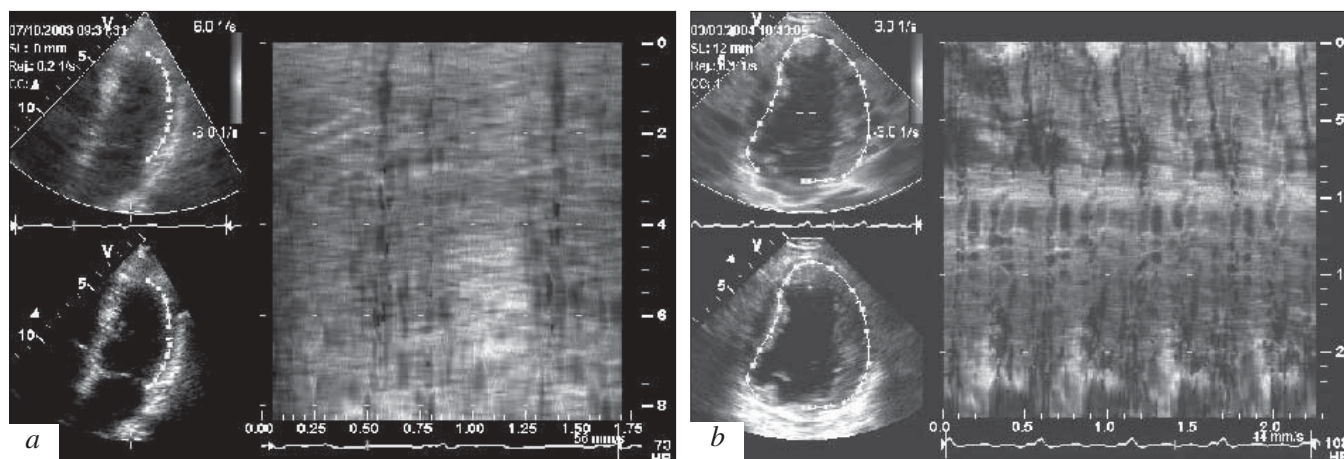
Echocardiographic (bent strain rate M-mode) examination of the hearts of coronary patients with different content of HSP70 inducible stress proteins. *a*) hypokinesia of the basal, middle, and apical segments on the lateral wall of the left ventricle; *b*) pronounced dyskinesia of the basal, middle and apical segments on the lateral wall of the left ventricle.
